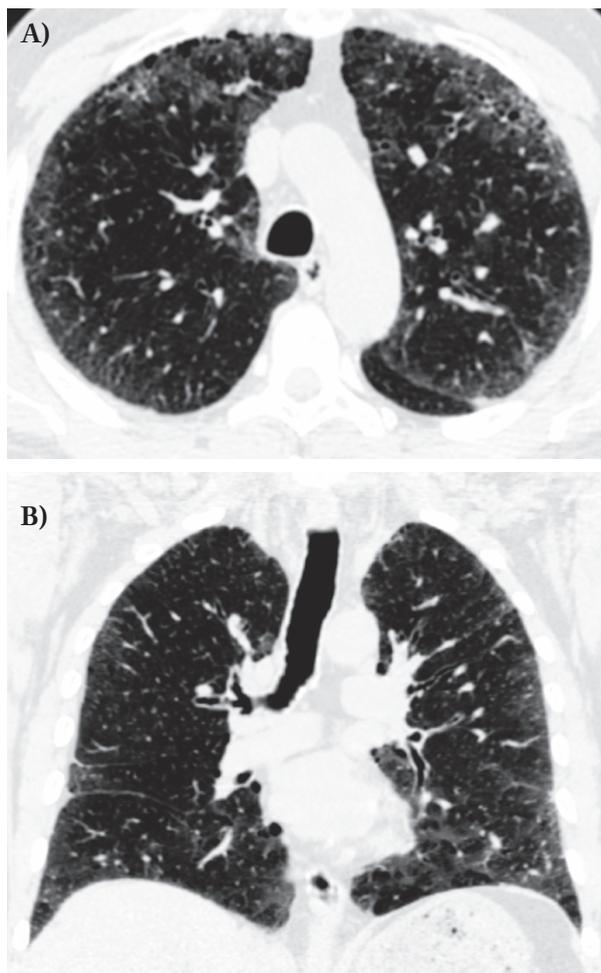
Shown are the axial (1 A) and coronal (1 B) reconstruction of a HRCT categorized, according to criteria exposed in table 1, as: 1) Subpleural, basal predominance NO; 2) Reticular abnormality YES; 3) Honeycombing with or without traction bronchiectasis YES; 4) Upper or mid-lung predominance NO; 5-10) other features inconsistent with UIP pattern NO
